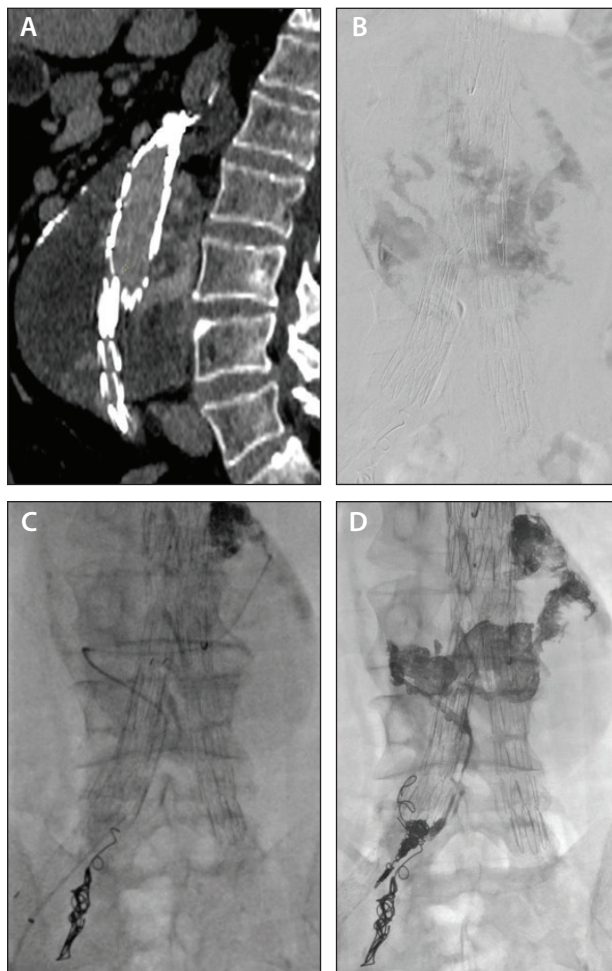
A male patient in his mid-70s with a 9.6-cm AAA after FEVAR with type II endoleak. Preprocedure delayed-phase CTA demonstrated endoleak evolving the L3 lumbar arteries (A). Endoleak arteriogram demonstrated the endoleak nidus (B). Perigraft embolization of the endoleak nidus with Onyx 34 (C). Completion imaging after Onyx 34 embolization of the nidus and coil embolization of the perigraft access site (D).
